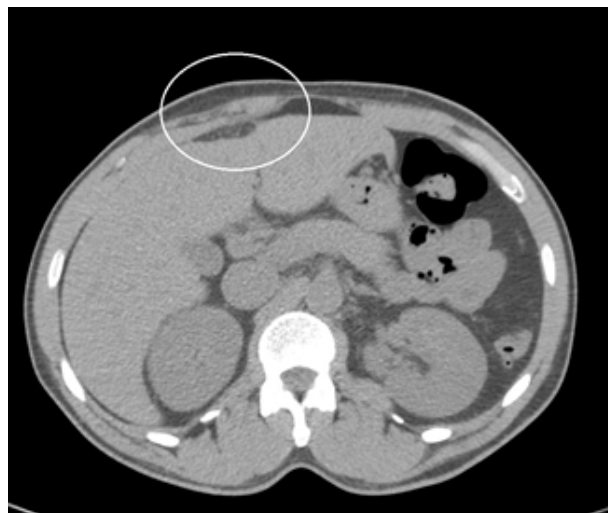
Axial CT image showing fat stranding in a lipomatous appendage of the falciform ligament compatible with infarction. The surrounding inflammatory changes in the adjacent fat and myofascial planes give rise to a subtle focal cutaneous lump, evident if we compare it with the contralateral side.
